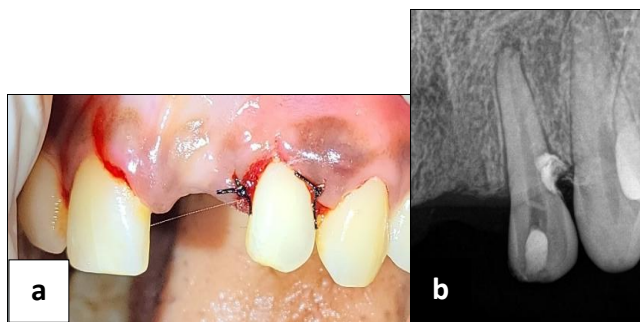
a) Immediate postoperative photograph; b) Immediate postoperative radiograph
